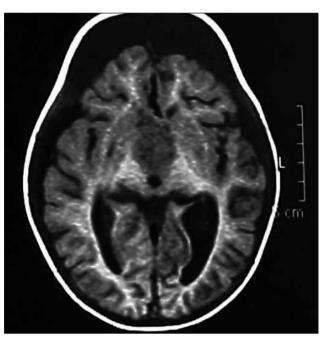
Three months after the operation (Case-2). Axial T1-weighted MR image demonstrating residual tumor at the primary site with resolution of the hydrocephalus causing frontoparietal subdural cerebrospinal fluid collection.
